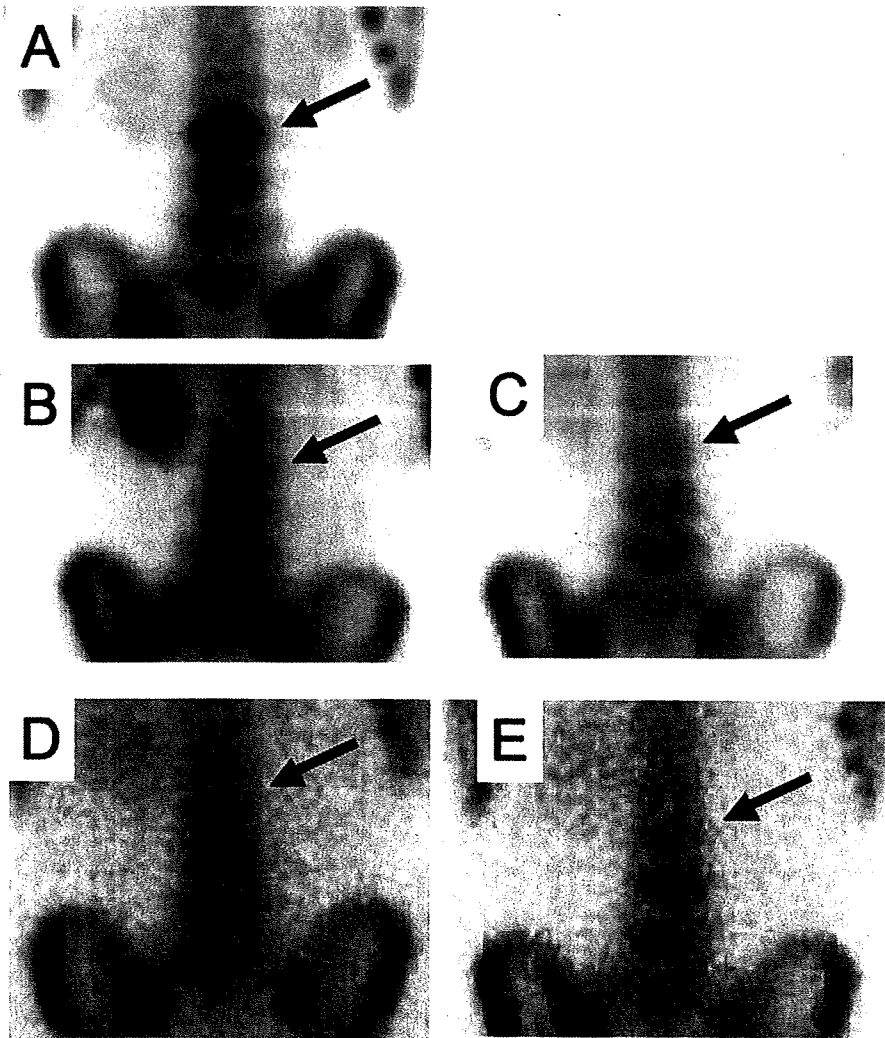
Control of new lesions of bone metastasis after the start of WT1 immunotherapy. (A) New lesions (L2, 3, 4) were observed on bone scintigraphy after two courses of combination chemotherapy. Bone scintigraphy before (B) and 3 (C), 14 (D), and 21 (E) months after WT1 vaccination. Scintigraphic uptake disappeared after vaccination. Arrow indicates L2 vertebra.
